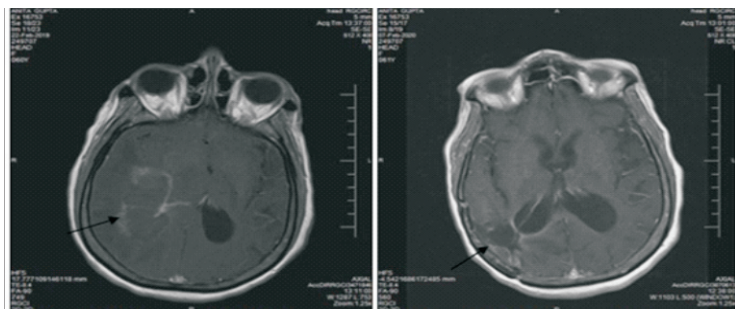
Right posterior temporal glioblastoma pre-op MRI
